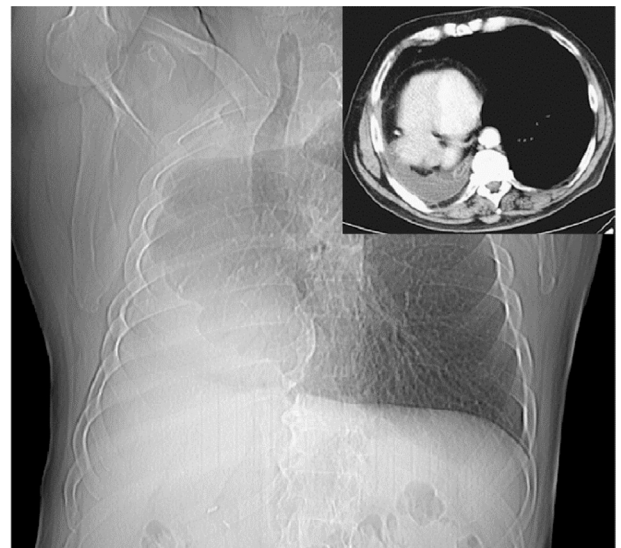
CT topogram and axial view (inlay) show the heart displaced to the right hemithorax.
